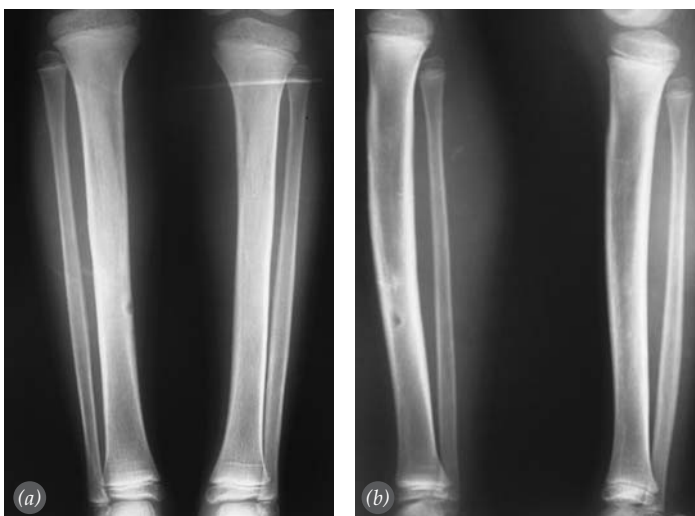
Anteroposterior (a) and lateral (b) radiographs of both tibiae after surgery. Note the curettage cavity in the right tibia.
